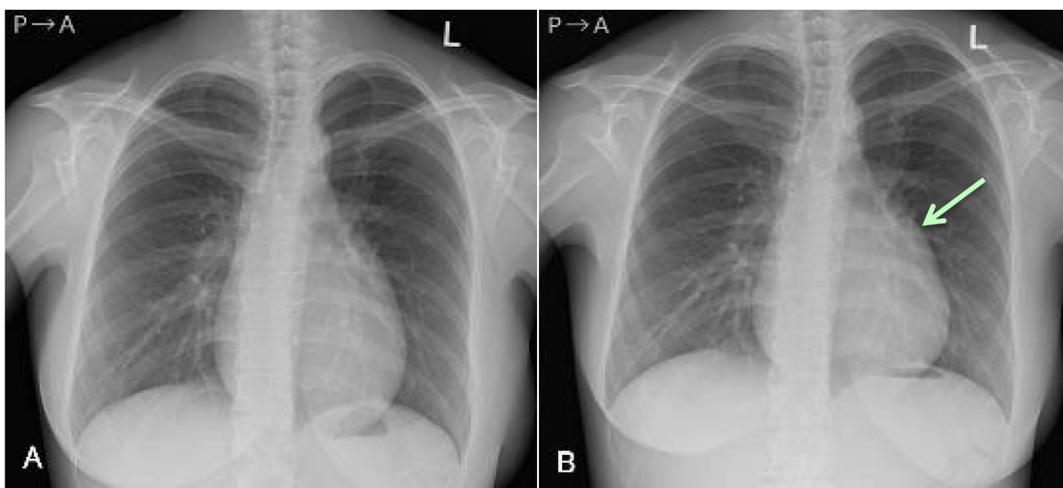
Chest radiographs (A) prior to the second pregnancy and (B) during the second trimester of the second pregnancy. (B) shows increased left atrial dilatation (arrow). The cardiothoracic ratio is $<50\%$ at both time points.
